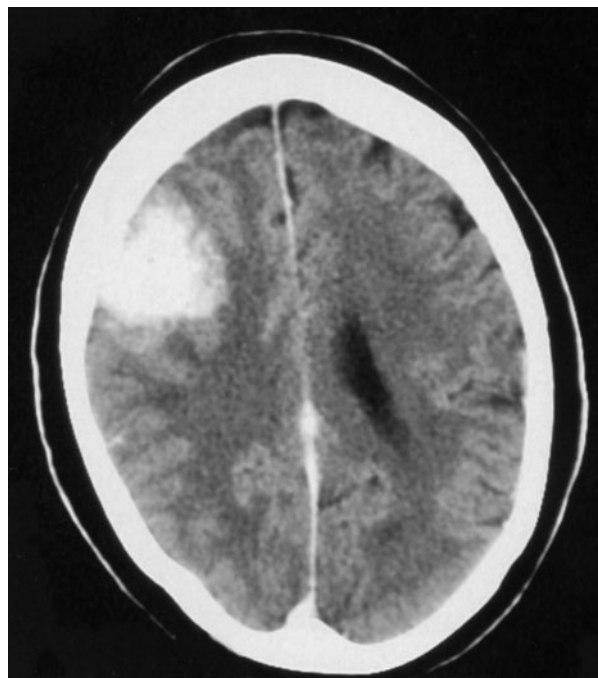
A non-contrast CT showing a right fronto-parietal tumour causing mass effect and slight midline shift.
